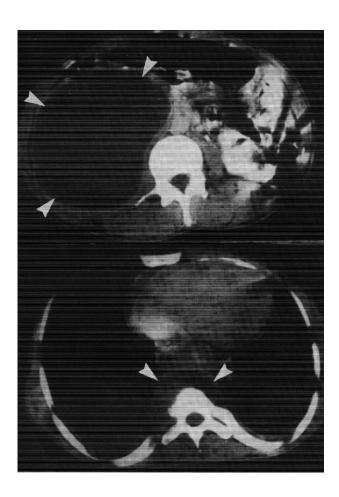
Computed tomographic scan, when the patient first presented: A (top). Abdominal section; B (bottom). Mediastinal section. Arrowheads delineate lymphangioma mass.
